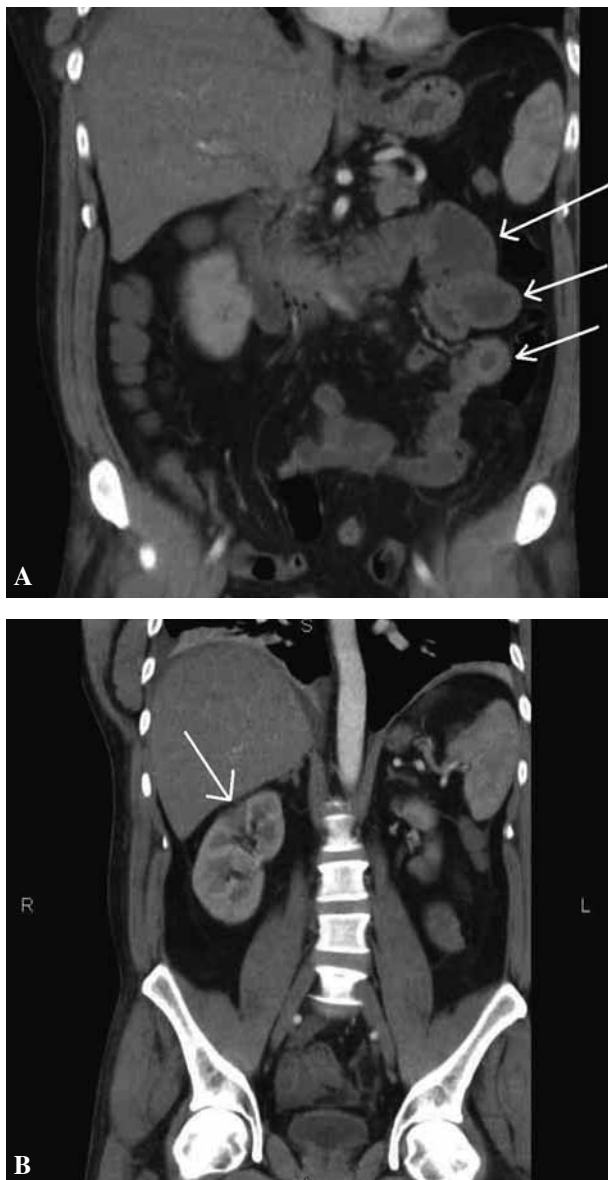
Abdominal CT with arterial contrast from the first admission with abdominal pain. White arrows show : A) Circumferential jejunal wall thickening. B) Decreased uptake of contrast in the upper pole of right kidney in keeping with infarction. C) Small filling defect in a segmental branch of SMA.
